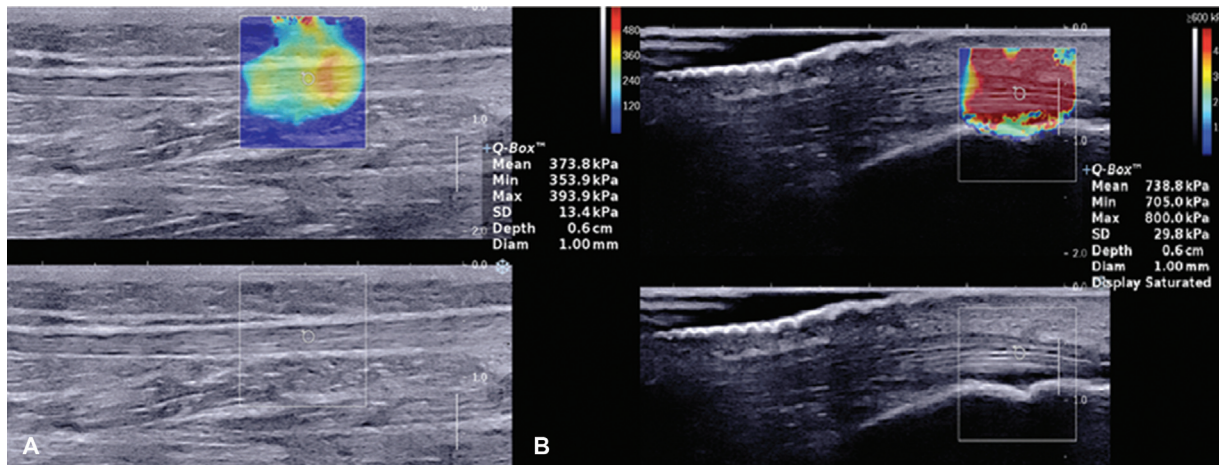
Sagittal gray scale (GS) ultrasound and shear-wave elastography (SWE) images of the Achilles tendon in a healthy volunteer. Dual-screen was used showing GS ultrasound image with an overlying elastogram. Images of middle third part of the Achilles tendon, (A) dual-screen SWE image showing color elastogram with circle representing the region of interest (ROI) where elastic modulus kilopascal (kPa) was measured with mean elastic modulus measuring 373.8kPa. Images of distal third part of the Achilles tendon, (B) dual-screen SWE image showing color elastogram with circle representing the ROI where elastic modulus kPa was measured with mean elastic modulus measuring 738.8kPa. Color ranges from blue (softer) to red (stiffer).
